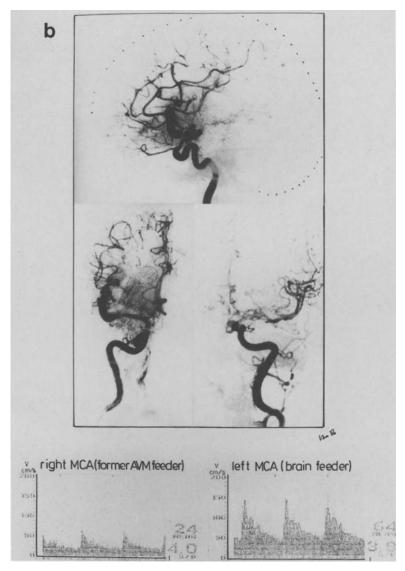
Doppler findings 7 days after removal of AVM and clipping of aneurysm that had not ruptured; the former feeder shows flow deceleration whereas in the contralateral MCA only slight changes have occurred
